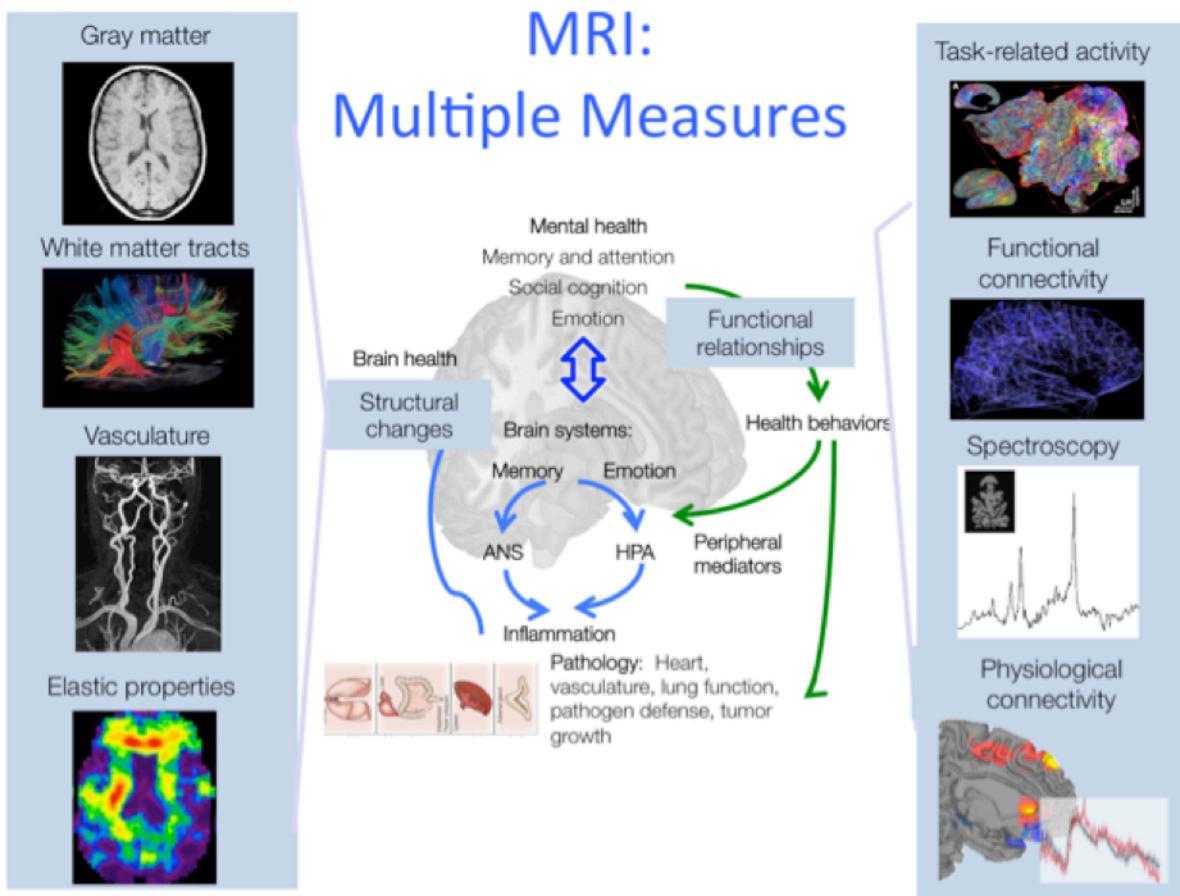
The multiple measures of MRI. In a single MRI session, we generally obtain multiple types of images related to diverse aspects of brain physiology. These measures can be associated with many aspects of cognitive function, emotional function, and peripheral physiology to provide a comprehensive set of relationships between the brain, the mind, and our health.
